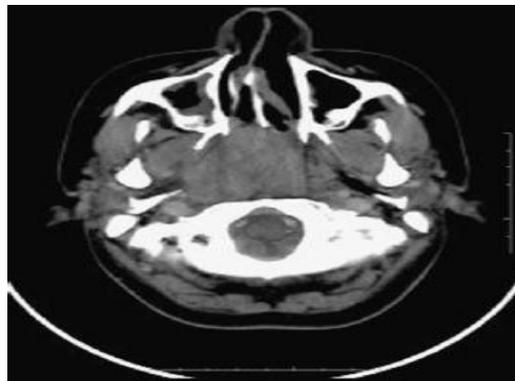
CT axial section after injection of iodinated contrast.
